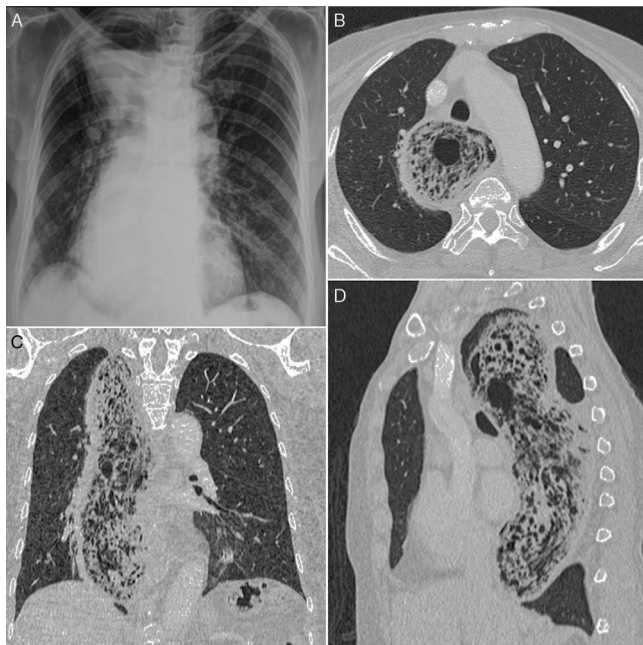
A chest radiograph (A) shows mediastinal widening with an air-fluid level, compatible with megaesophagus. Axial (B), coronal (C), and sagittal (D) reformatted CT images reveal marked esophageal dilatation with residue and multiple air bubbles.
